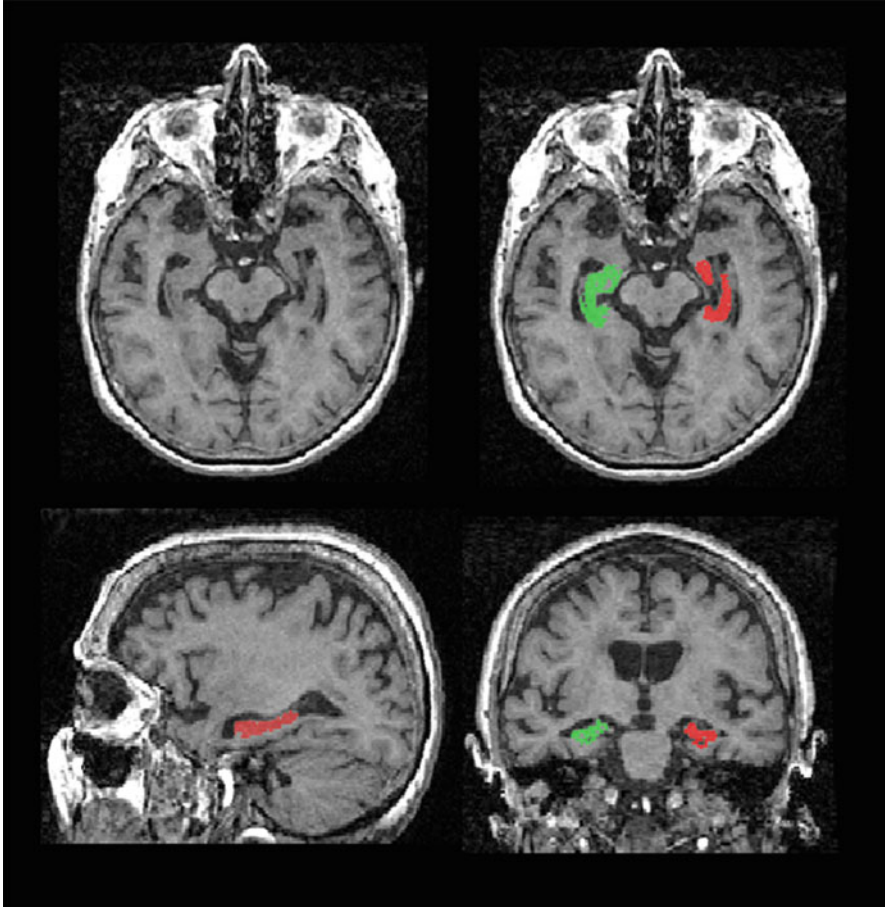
A binary mask, representing the hippocampi as a specific region of interest, is displayed as an overlay on its T1-weighted image and viewed in axial (*top right*), sagittal (*bottom left*), and coronal sections (*bottom right*)
